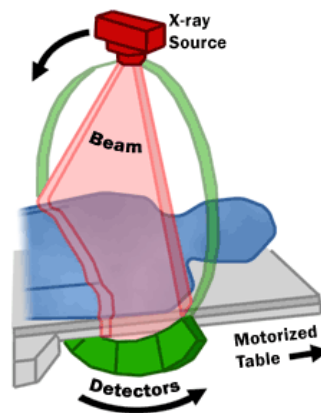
Scheme of how a X-ray machine or a CT scan works
